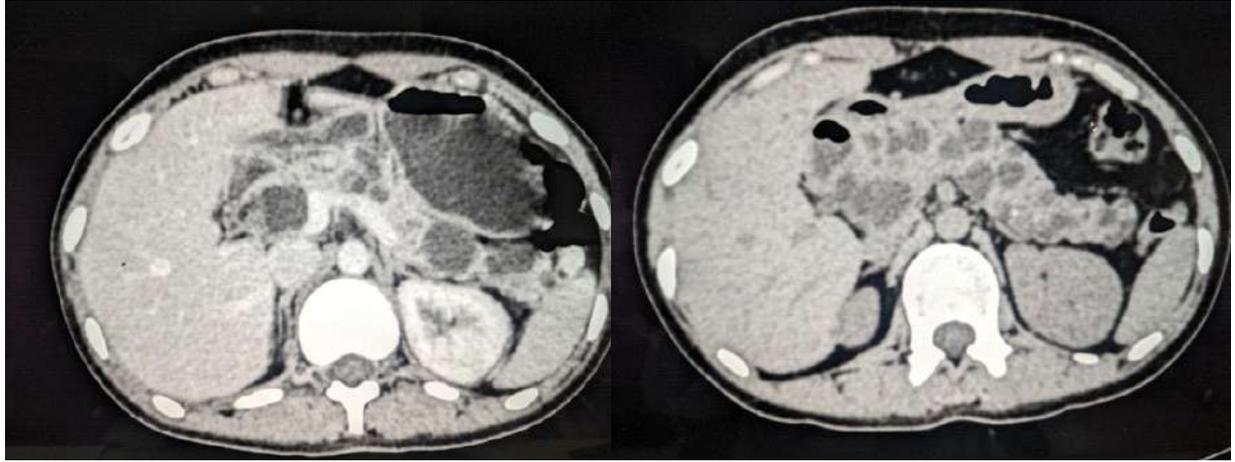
Contrast enhanced CT scan shows mild peripherally enhancing variable sized cystic lesions.
